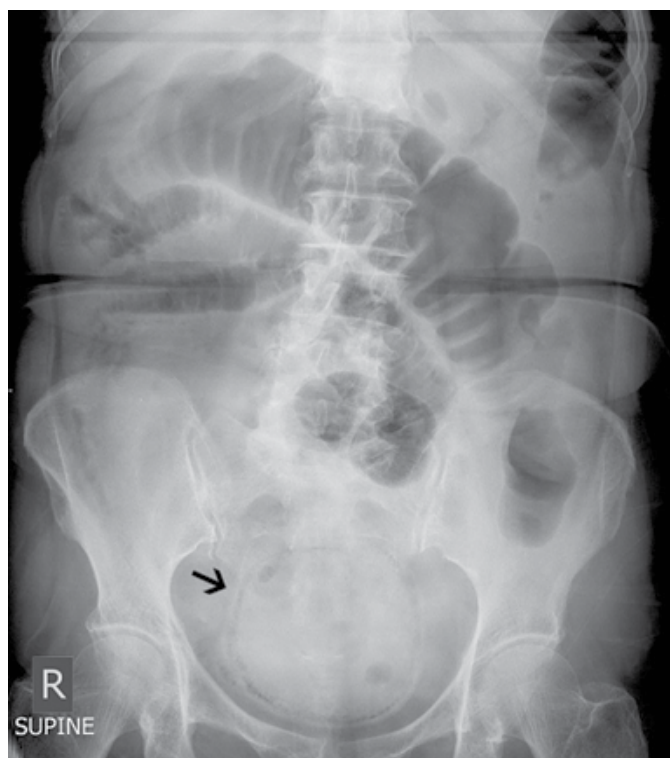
Plain supine abdominal X-ray of the patient showing a circular radiolucent rim (as indicated by the arrow) at the expected position of the bladder in the pelvis suggestive of emphysematous cystitis.
